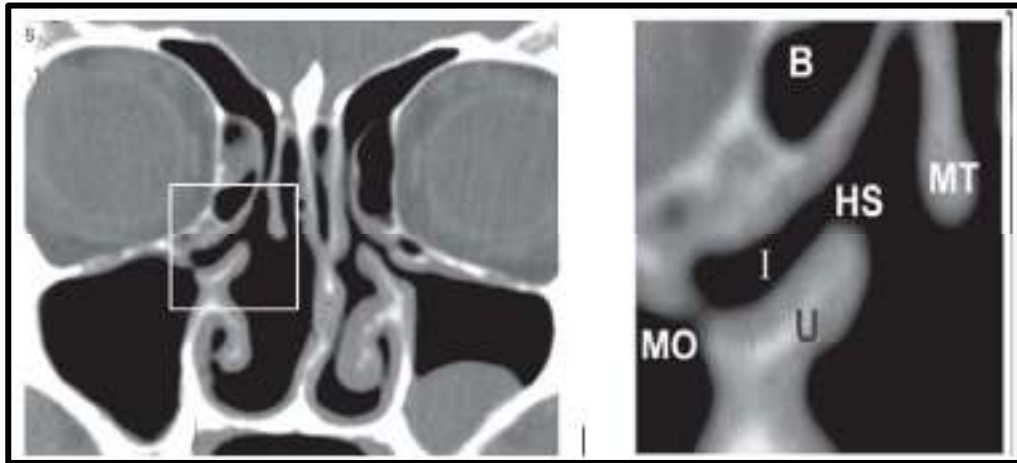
CT-Scan PNS Coronal view – Osteomeatal complex.³⁶
